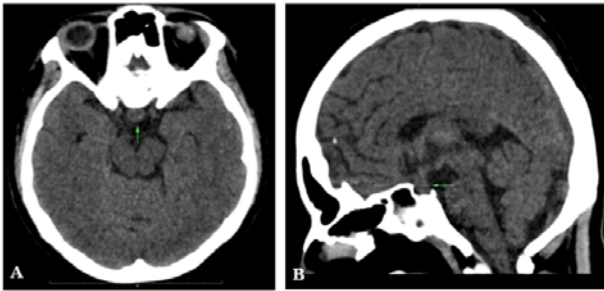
CT brain axial (A) and sagittal (B) view showing enlarged pituitary with prominent stalk
